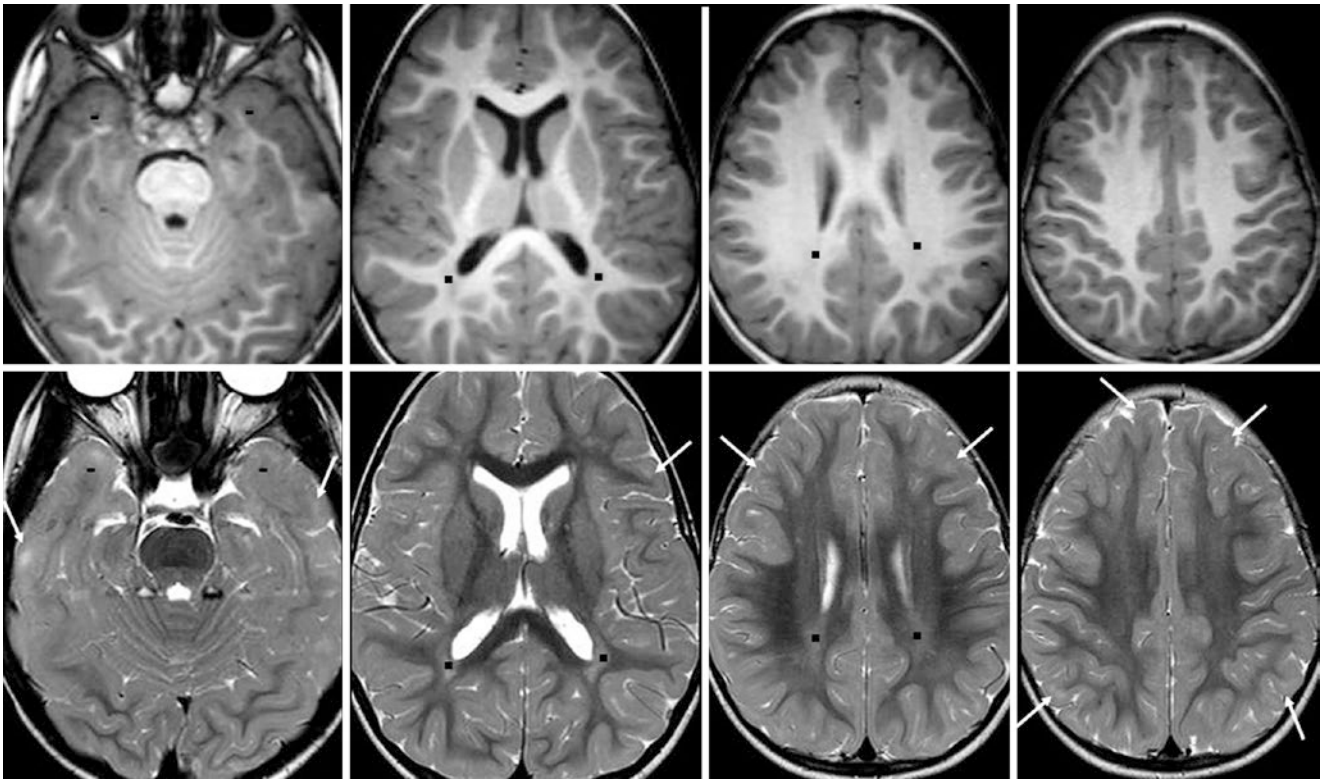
Minimal “patchy” SCWM. A 17.5-month-old with seizures had a 3T MRI, with a normal myelination pattern on GE T1WIs (top row) and SE T2WIs (bottom row). There is only minimal SCWM hyperintensity (thin arrows), which is most visible within the anterior
